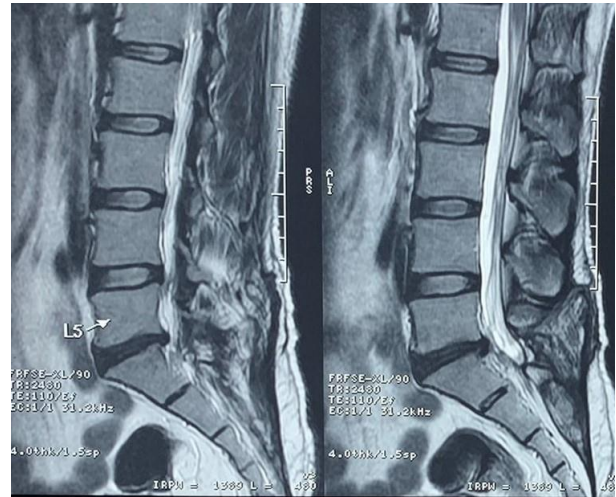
Post-operative sagittal MRI image of same patient as in Figure-3.
